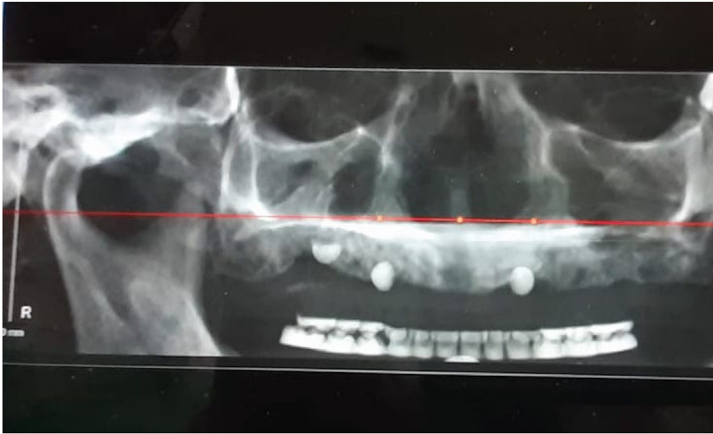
Preoperative radiographs, showing the situation of the patient with edentulous maxillary bone and dysmorphia due to maxillary hypoplasia: (a) panoramic view; (b) lateral view.
